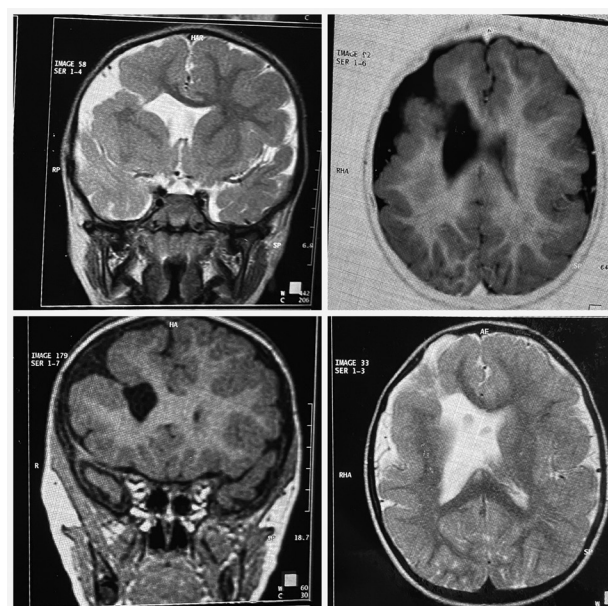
MRI scans showing a cleft opening to ventricle at right anterior frontal lobe
